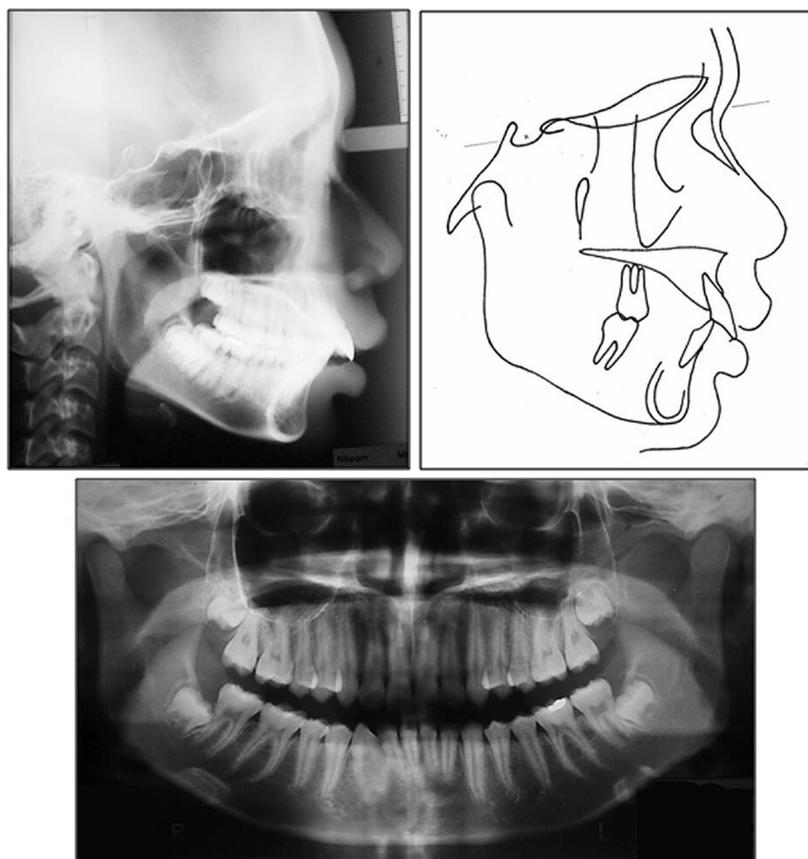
Pretreatment cephalometric radiograph, cephalometric tracing, and panoramic radiograph.
